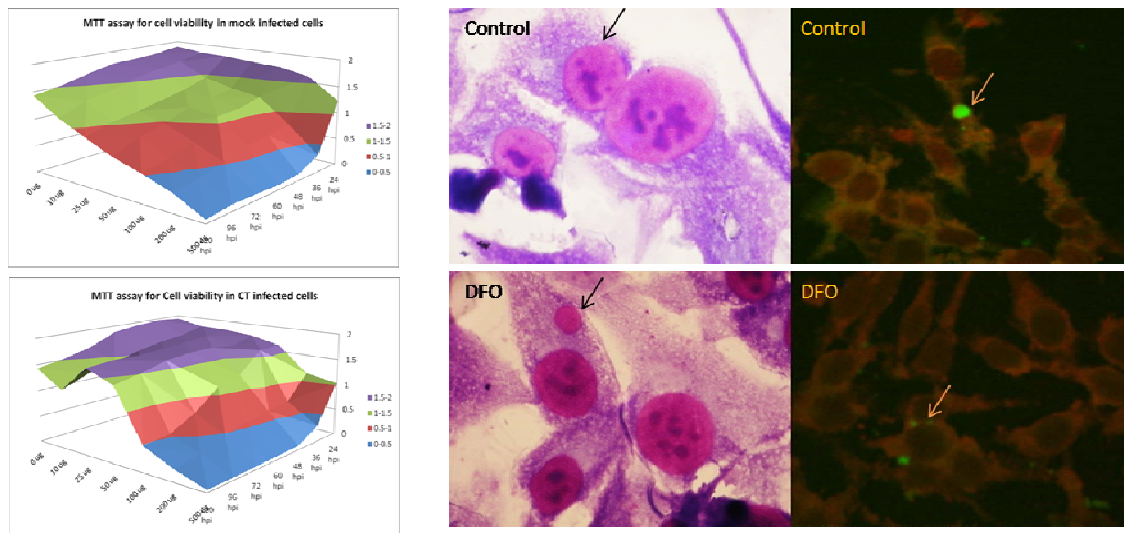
Cellular sustenance increases in CT infected cells at lower concentration of DFO (A) Surface plot showing OD values (570/620) obtained in MTT assays. Area under purple
